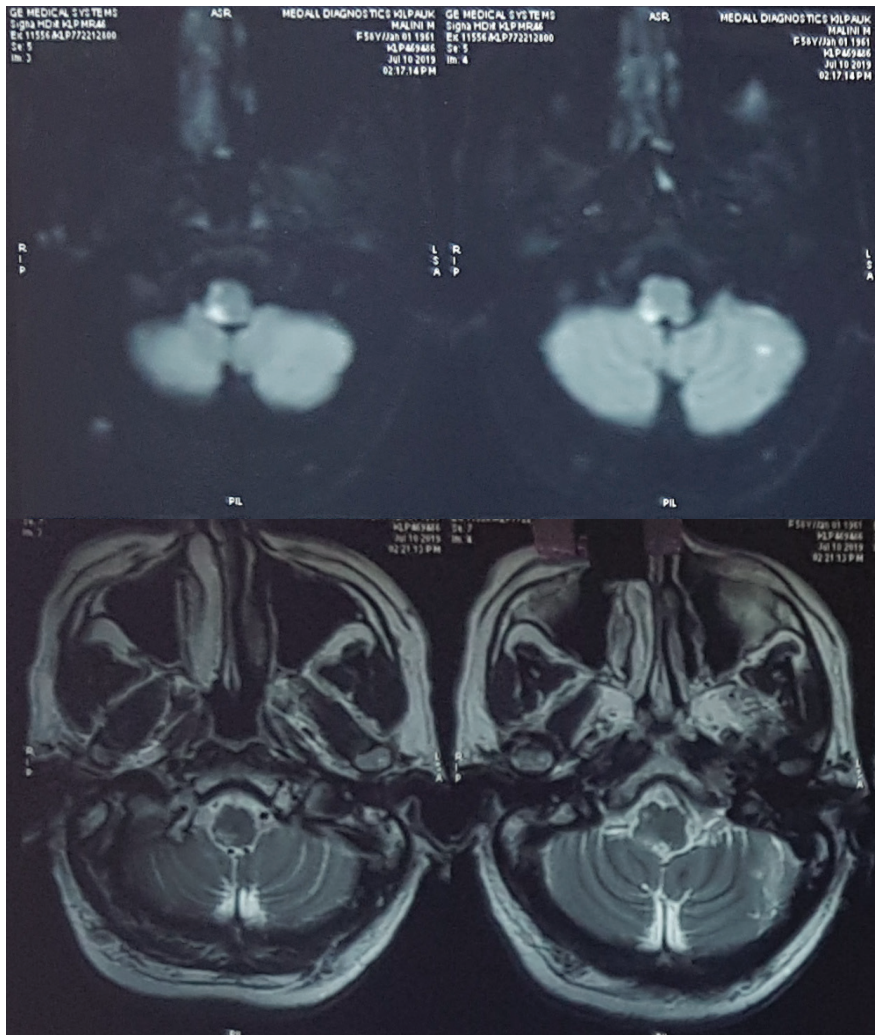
MRI brain showing diffusion restriction in right dorsolateral part of medulla.
